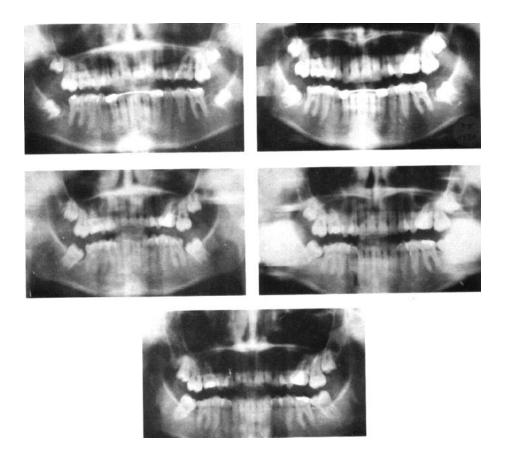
Case D, Class II, girl 12 years old at time of second molar extraction. Final radiograph, age 19, shows axis of tooth 48 continuing to improve even after closure of the extraction space.
